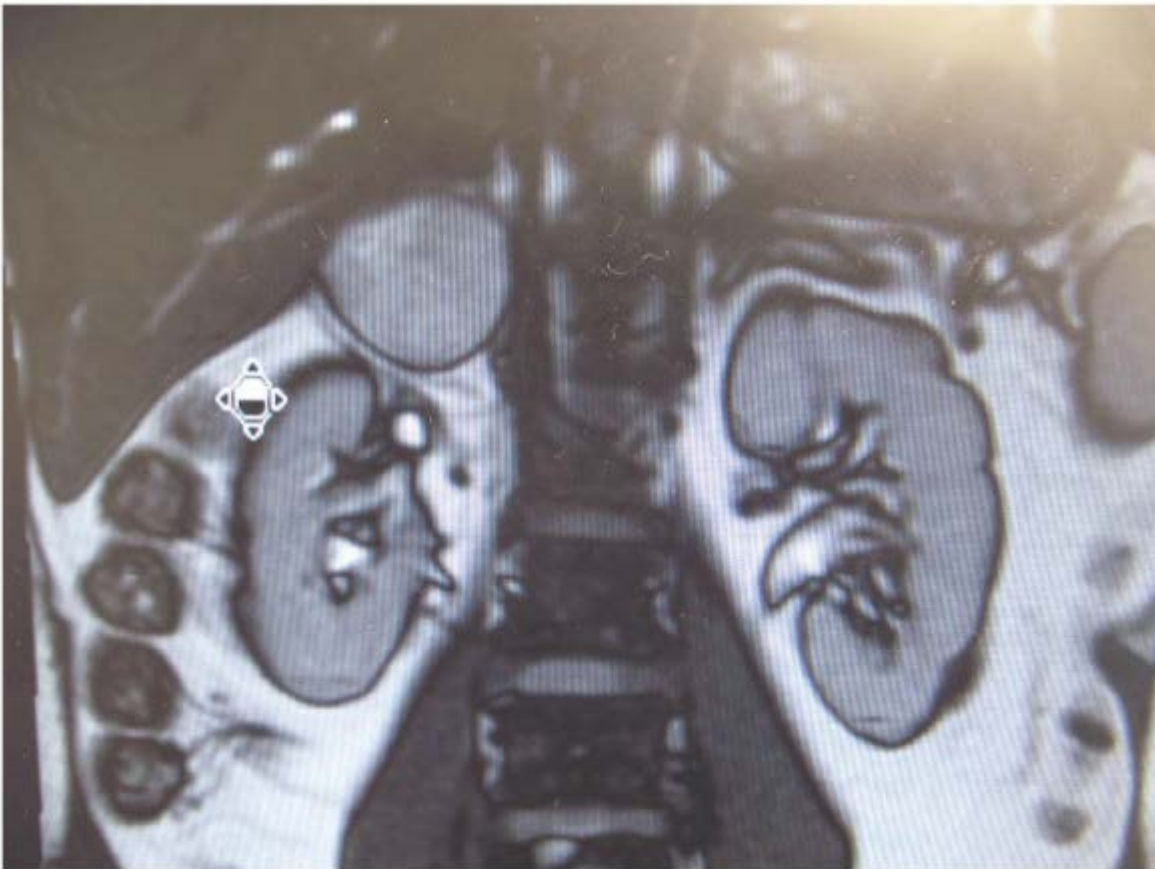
MRI T2-weighted image showing typical appearance for pheochromocytoma.
